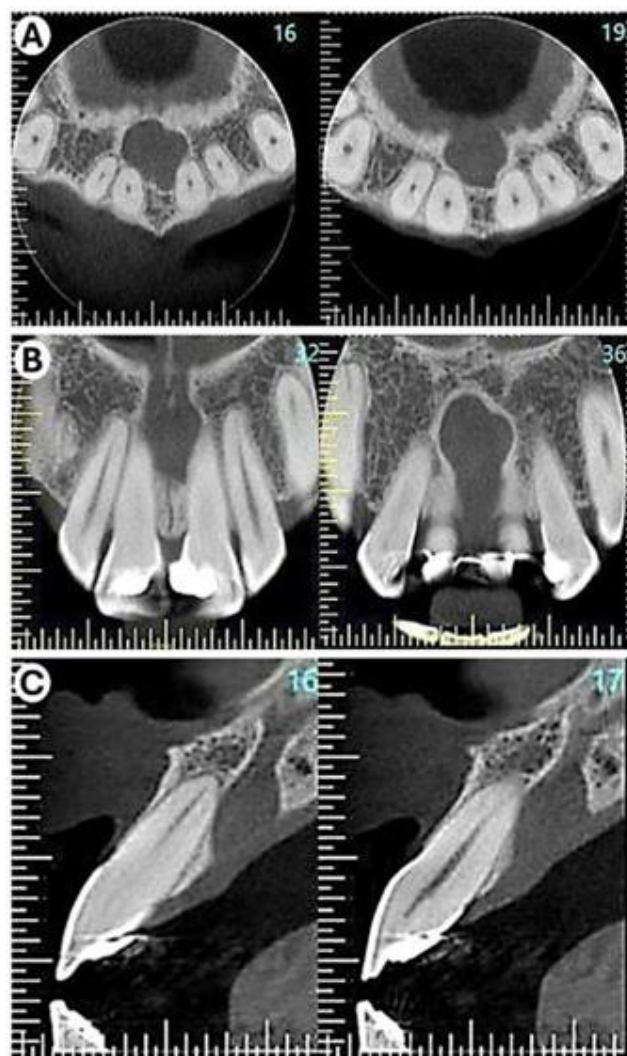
Cone Beam computed tomography of the maxilla for preoperative evaluation. A: Axial section; B: Coronal section; C: Sagittal section (Source: Authors).
